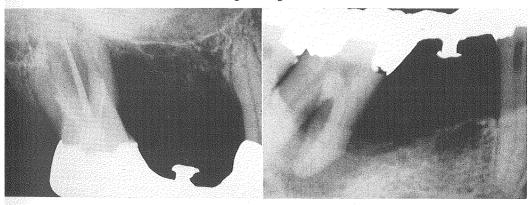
(*Top*). Roentgenograms taken before and after stress. FIG. 23 (*Bottom*). Fixed bridges using the same occlusal restorations.
